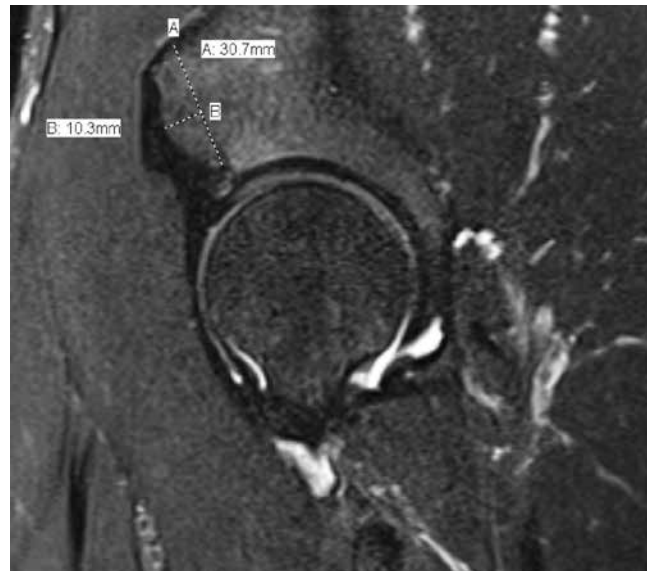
Measurement of the length (10.3 mm) and height (30.7 mm) of the anterior inferior iliac spine using sagittal view MRI.
